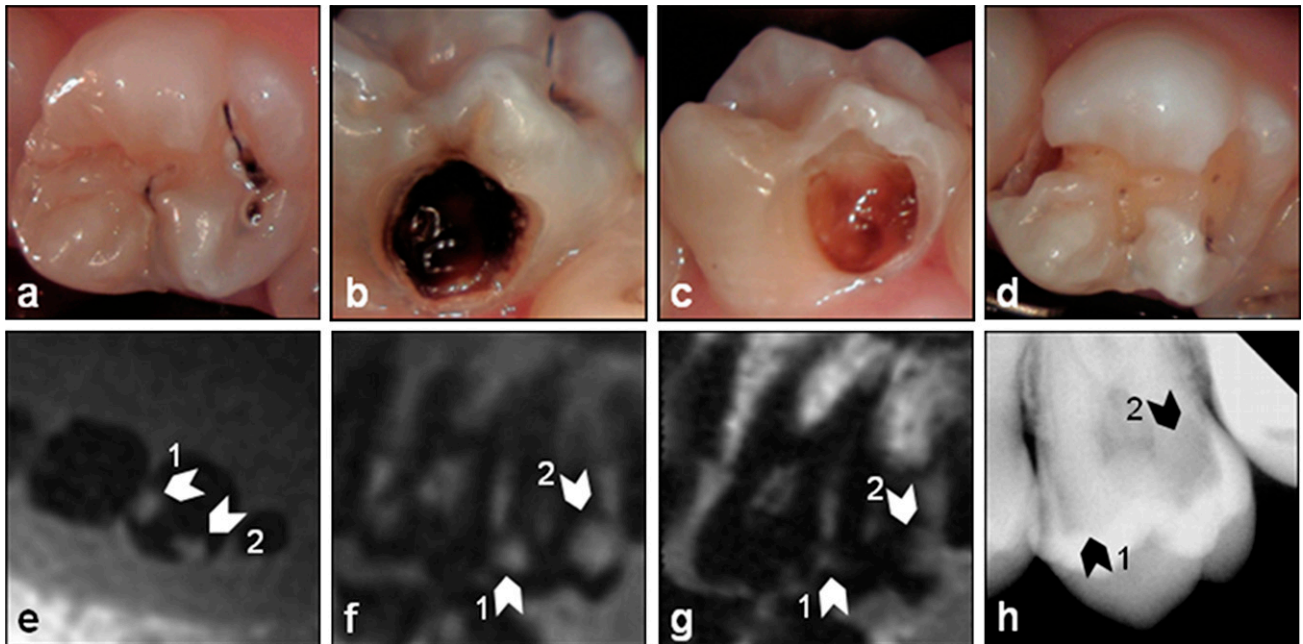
Smooth surface caries (CI): intraoral images (a, occlusal; b, bucal) prior to the dental treatment and the images (c, bucal; d, occlusal) after excavation of the lesions and the respective (e) transversal and (f) parasagittal three-dimensional ultrashort echo time (g) multislice turbo spin-echo and (h) X-ray images of the tooth. The white arrows in the MR images and the black arrows in the X-ray image indicate the lesions
